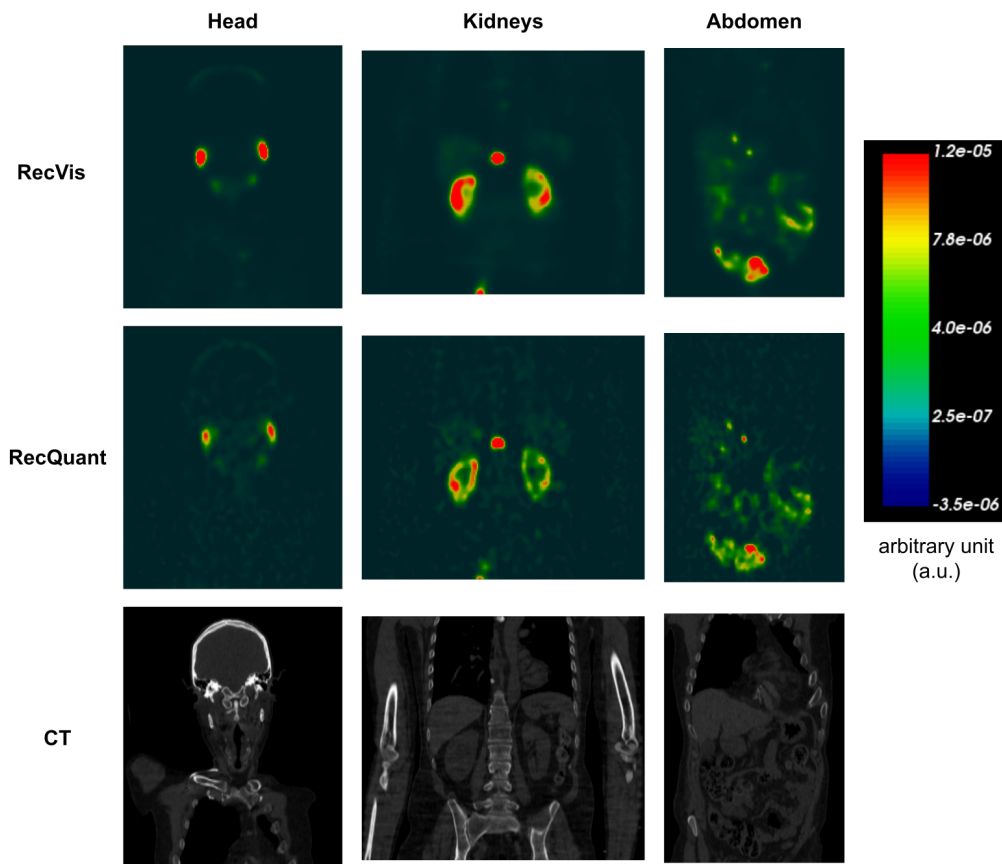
Normalized SPECT reconstructions (RecVis and RecQuant) in arbitrary unit of a patient treated with ^{177}Lu -PSMA-1 24H after the first injection. The focus is on three regions: the head, the kidneys and the abdomen. Associated CT scans are also available.
